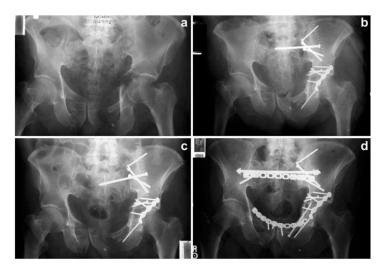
radiographic pictures of a T-shaped acetabular fracture and a concomitant left SI fracture-dislocation (A). Following fracture fixation (B), the posterior pelvic fixation failed (C), requiring revision with anterior ring fixation, a posterior tension band plate, and a trans-sacral screw. (D) (Timmer et al., 2023).
